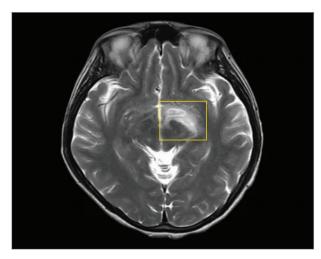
Magnetic resonance imaging (T1-weighted, gadolinium-enhanced) demonstrated an about $30.6 \times 12.8 \times 17.6$ -mm lesion with an enhanced annular edematous edge (yellow box) in the left dorsal thalamus.
